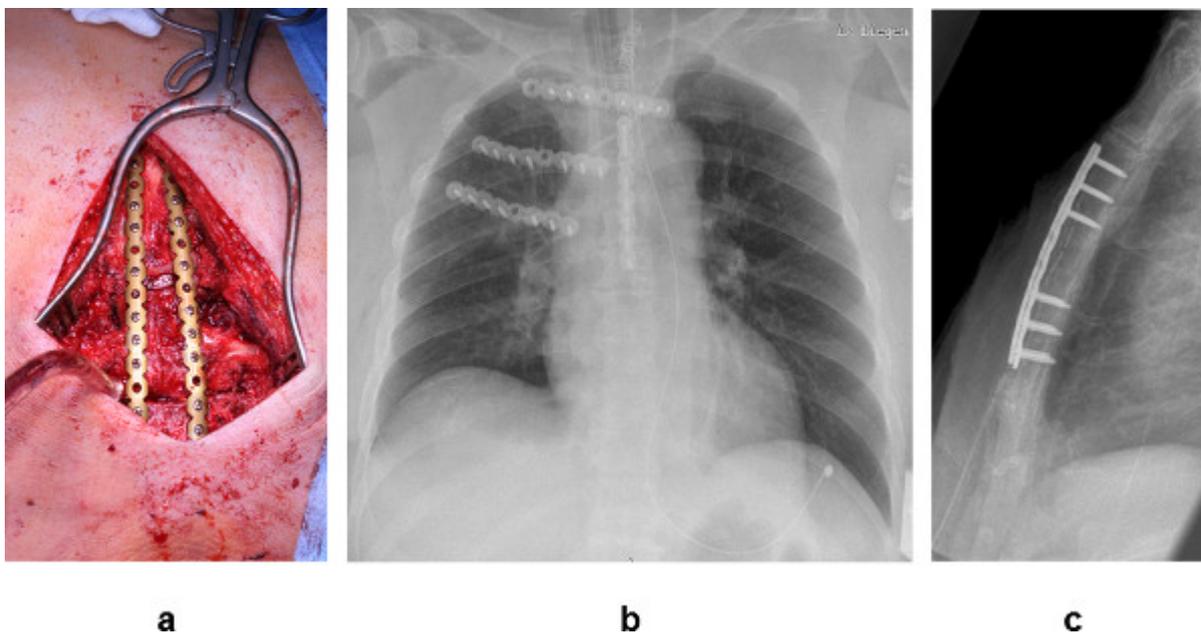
Operative results. (a) Long parallel plates, each fragment was fixed with 3 screws. (b) Postoperative chest x-ray showing longitudinal sternal plate and three transverse plates fixing oblique manubrium fracture, sternocostal separation of second rib and fracture of third rib on the right side. (c) Lateral view of x-ray shows correct position of two parallel plates fixing a fracture located at sternal corpus.
